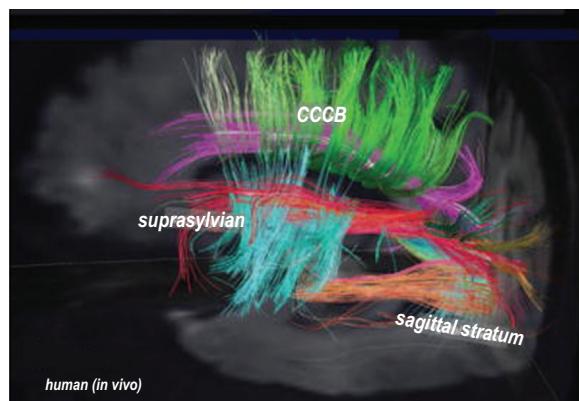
A cerebral grid structure of the human brain showing the plan of the fibre pathways; image taken using diffusion magnetic resonance imaging. (From Wedeen et al., 2012.)
